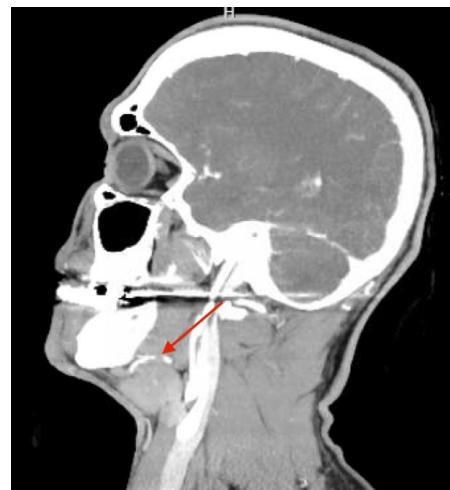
CTA head and neck showing traumatic occlusive dissection of the right facial artery (arrow).
